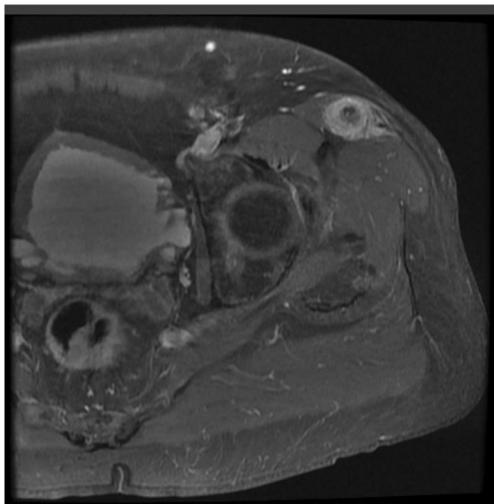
Axial fat-suppressed T2-weighted magnetic resonance image showing a 2.2 × 1.8-cm mass in the left sartorius muscle
